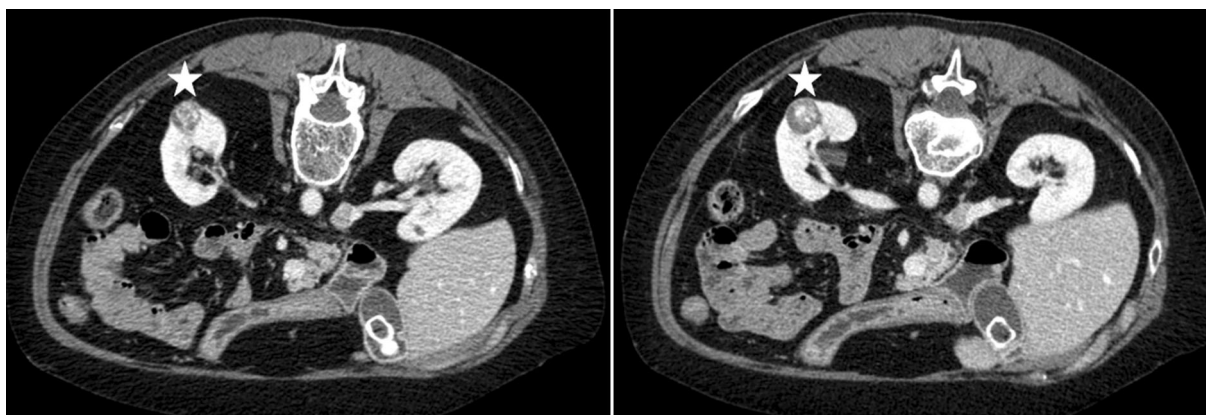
Exemplary preoperative CT scans of one case (patient #1 in Table 4) with intra- and postoperative bleeding (transverse plane; renal lesion in left kidney marked with a star)
